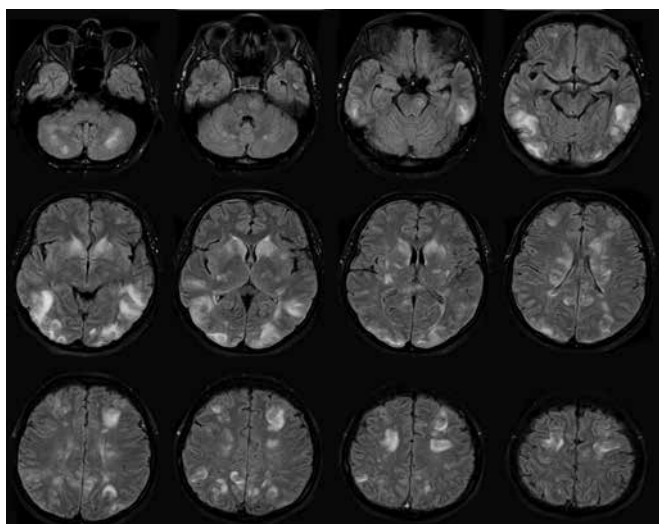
MRI FLAIR images show bilateral multiple subcortical and cortical hyperintense lesions.
